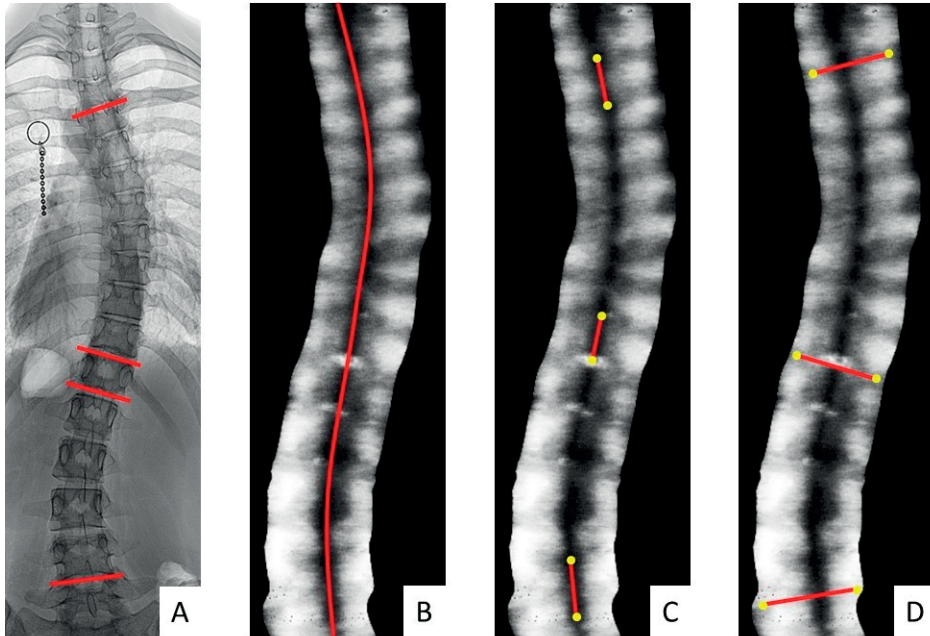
The coronal Cobb angle, measured on radiographs (A), was compared to three coronal ultrasound angles based on the spinous processes (SP) and transverse processes (TP), as marked in yellow: the automatic SP angle (B), the manual SP angle (C) and the manual TP angle (D). The most tilted SP line (between two SPs) at the upper thoracic region and the most tilted SP line (also between two SPs) at the lower thoracic region were used to calculate the thoracic SP angle and the same applied for the (thoraco) lumbar SP angle. TP lines were manually drawn between the right and left TPs of each vertebra. The angle was calculated between the two most tilted TP lines.
